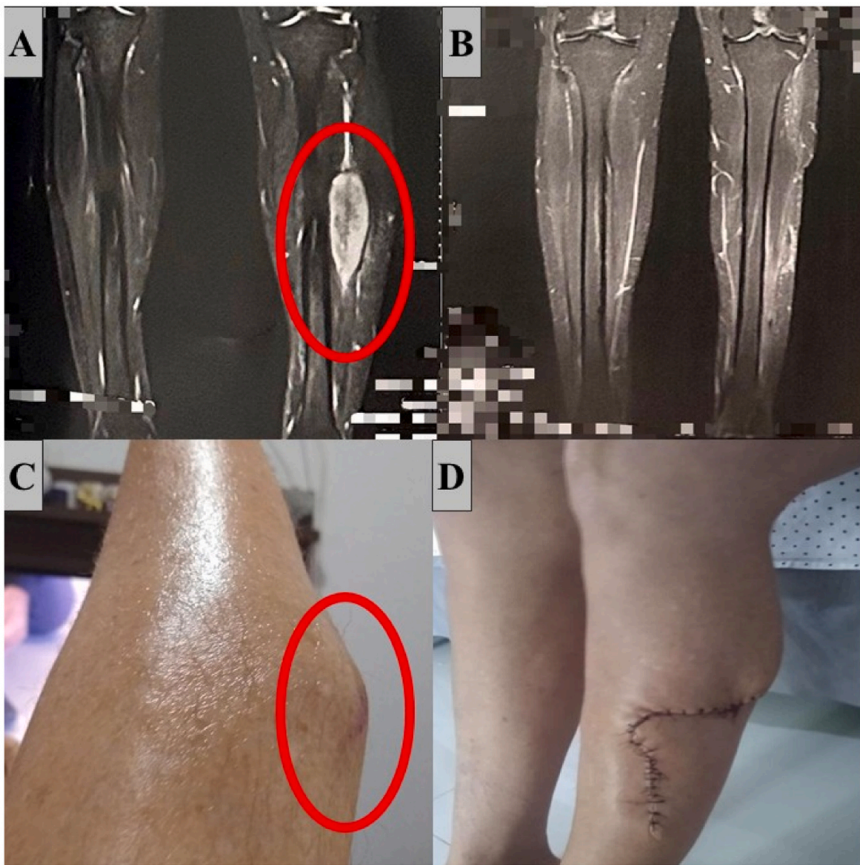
Magnetic resonance imaging (MRI) and clinical photographs of the patient's lower limb before and after surgical resection of a solitary fibrous tumor (SFT). (A) Preoperative MRI showing a well-defined mass in the anterolateral compartment of the left leg, without invasion of adjacent vascular structures. (B) Postoperative MRI demonstrating the absence of the previously identified lesion, consistent with complete resection. (C) Clinical image of the patient's leg showing the tumor before surgery. (D) Postoperative clinical image displaying the surgical scar after tumor excision.
